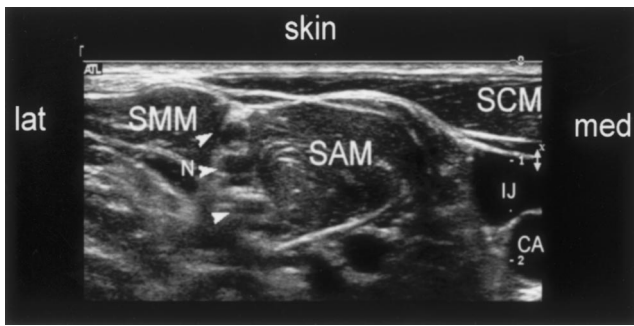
Transverse sonogram in the interscalene region showing brachial plexus as hypoechoic nodules (N with arrows) interposed between scalenus anterior (SAM) and medius (SMM) muscles, beneath the posterior margin of the sternocleidomastoid muscle (SCM). CA = carotid artery; IJ = internal jugular vein.
